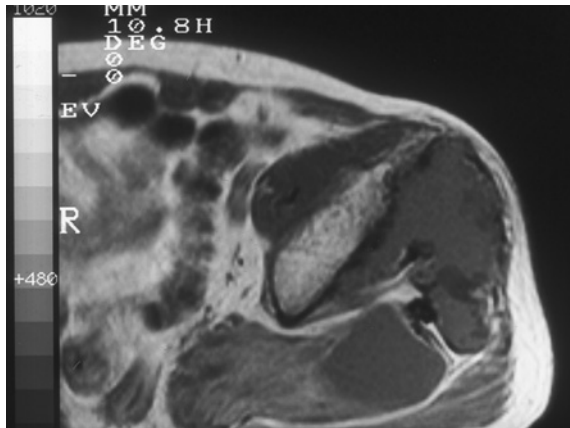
T1-weighted axial magnetic resonance image demonstrating that the part of the cystic lesion over the piriformis muscle is enhanced after gadolinium administration, whereas almost all parts of the cystic lesions over the gluteus medius and gluteus minimus muscles are not enhanced.
